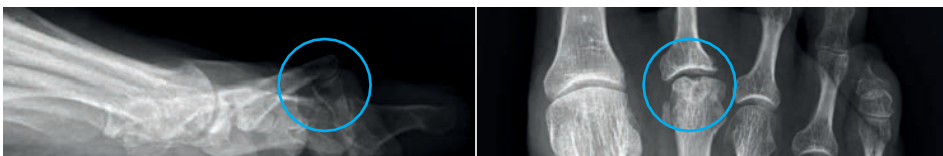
X-ray image with hammer toe formation on the left and osteoarthritis in the basal joint on the right.
